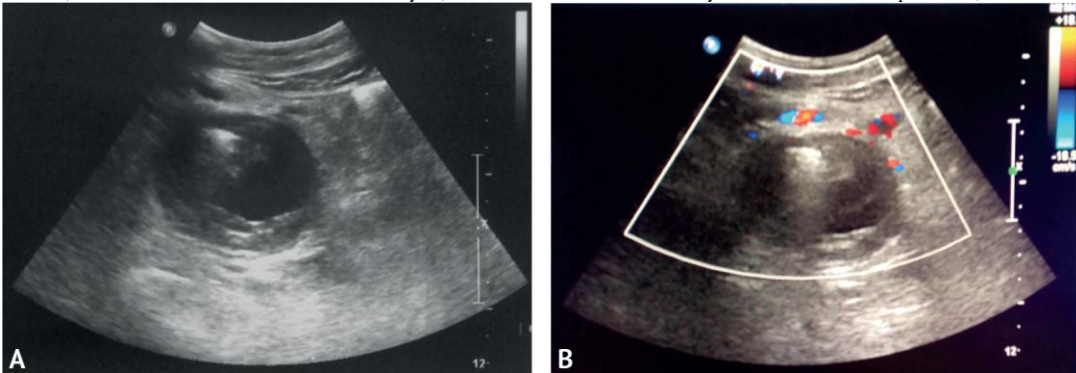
A — ultrasound examination of a false aneurysm, embolizing coils and thrombotic masses are visualized; B — ultrasound examination in the color Doppler mode, no blood flow in the false aneurysm
